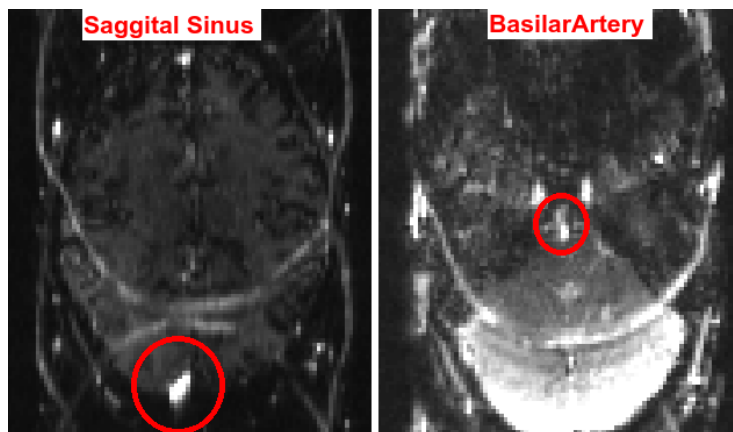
Example images acquired via an IR-LL-EPI MRI sequence containing the sagittal sinus (left) and the basilar artery (right)
